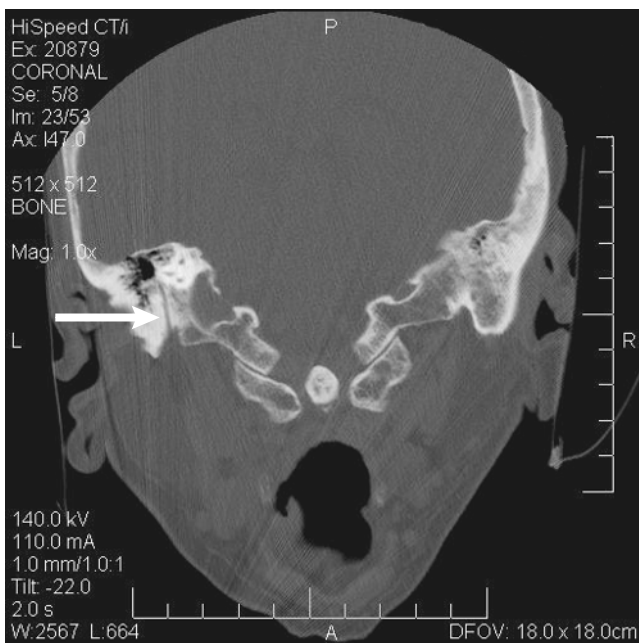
Coronal computed tomographic scan view of the descending (mastoid) portion of the facial nerve canal within the mastoid bone (white arrow).
